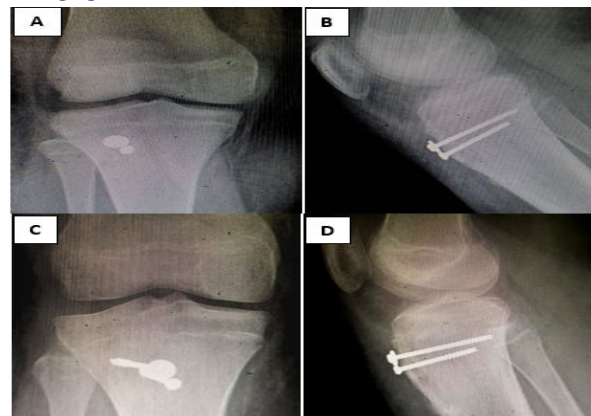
4th (A and B) and 5th (C and D) month follow up radiographs.
